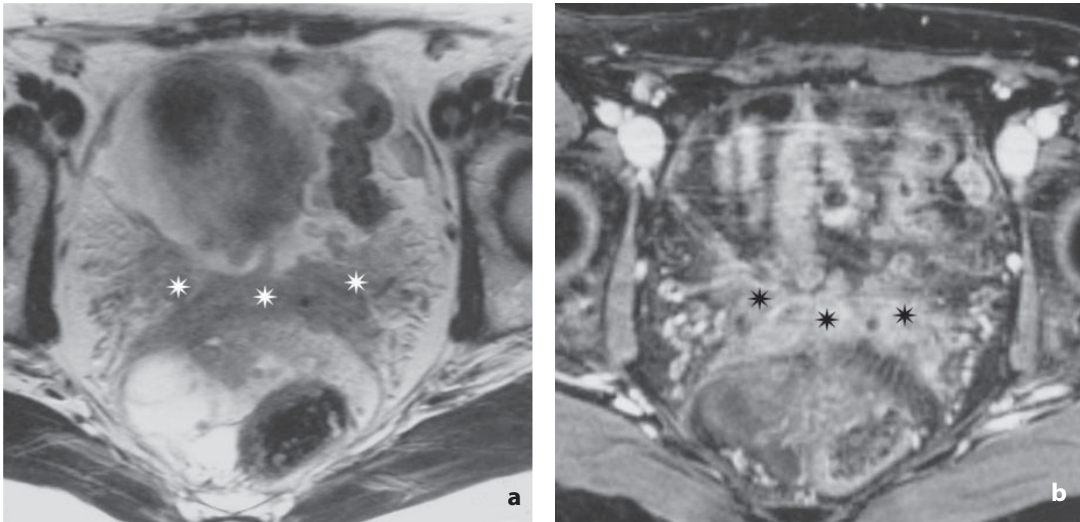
Magnetic resonance. Pelvic recurrence of ovarian cancer. T1-weighted image (a) shows a solid plaque (asterisks) with irregular margins and significant enhancement after injection of paramagnetic contrast medium (b)
